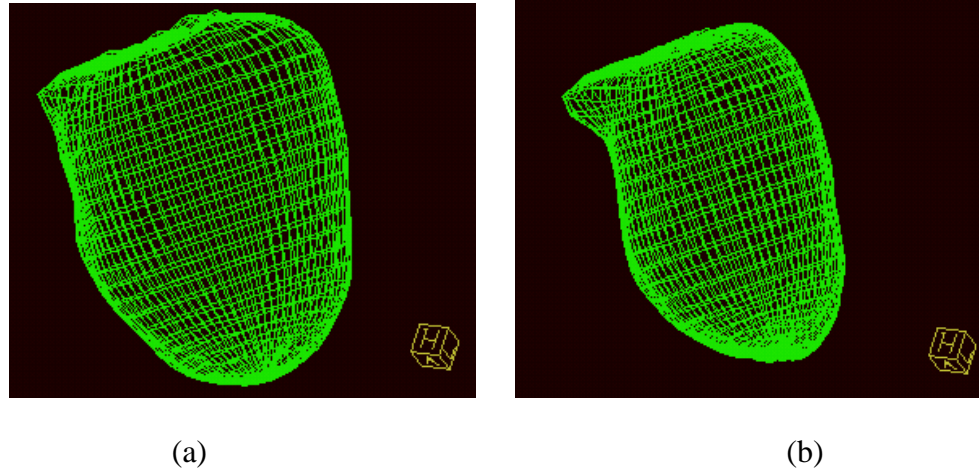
Epicardium (a) and endocardium (b) models of the LV identified in the CTA for Patient 1.
